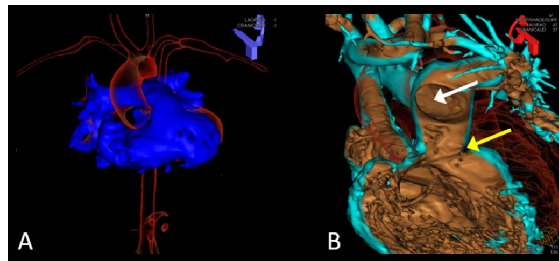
Visualization options for MRI-derived surface models. (A) Two surfaces loaded; the right side of the heart (blue) is solid rendered, the left side of the heart (red) is contour rendered. (B) Solid-rendered surface carved open to visualize the relationship between a stenosis (yellow arrow) and the right pulmonary artery ostium (white arrow).
